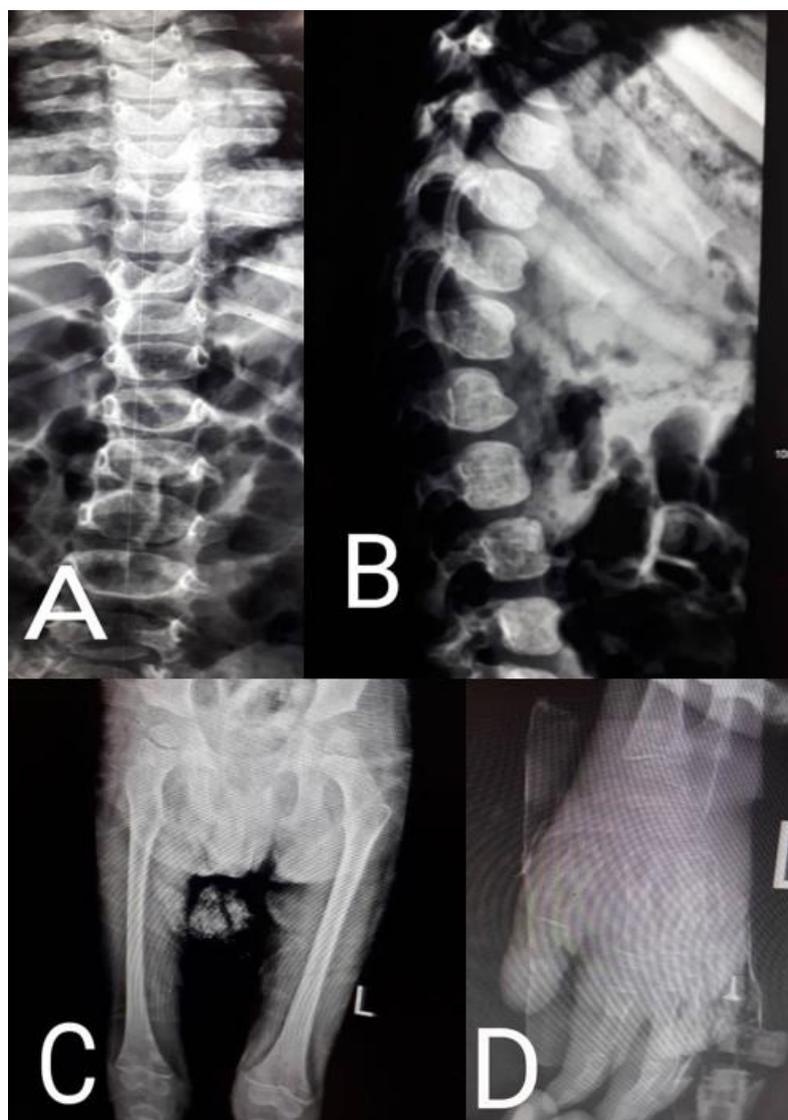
X-Rays: A. oar-shaped / paddle ribs. B. anterior breaking of thoracolumbar spine and hypoplastic vertebral body result in kyphosis. C. bilateral hypoplasia of pubic bones and irregular and flat acetabula. D. hypoplastic and broad first metacarpals, pointing of the third and second metacarpals, proximal bulging of metacarpal bone and angulation of the distal ulnar and radial metaphysis.
